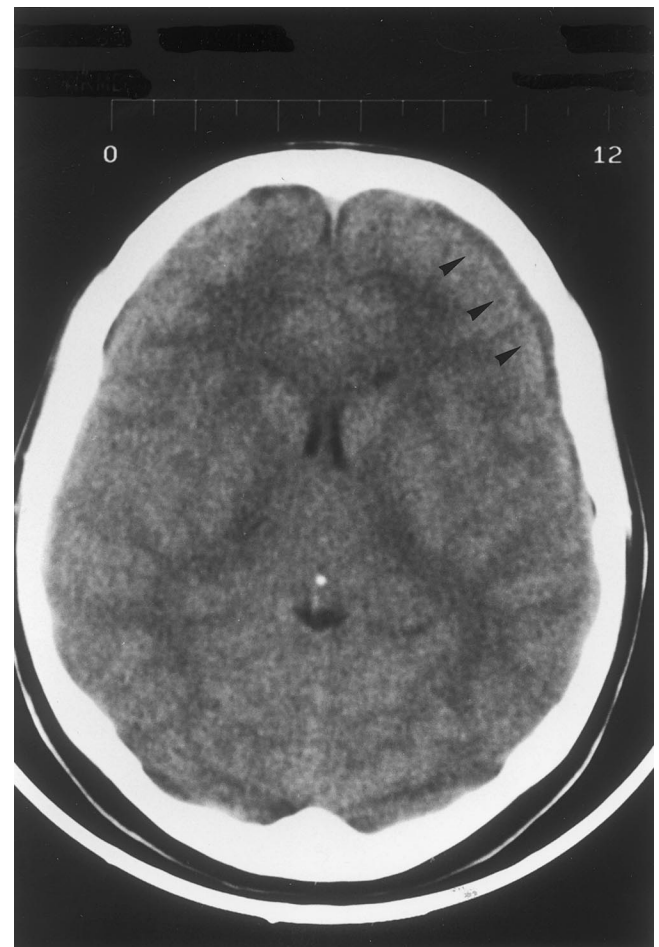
Cranial computed tomography showing frontoparietal hygroma (black arrowheads).
